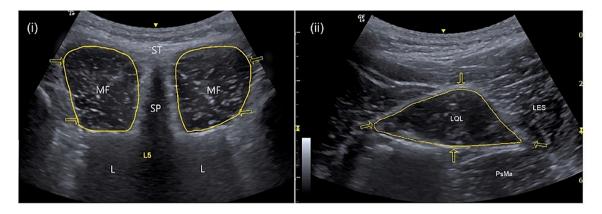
Transverse ultrasound images of the (i) multifidus and (ii) quadratus lumborum muscle with borders outlined to demonstrate segmentation for measurement of muscle CSA.
